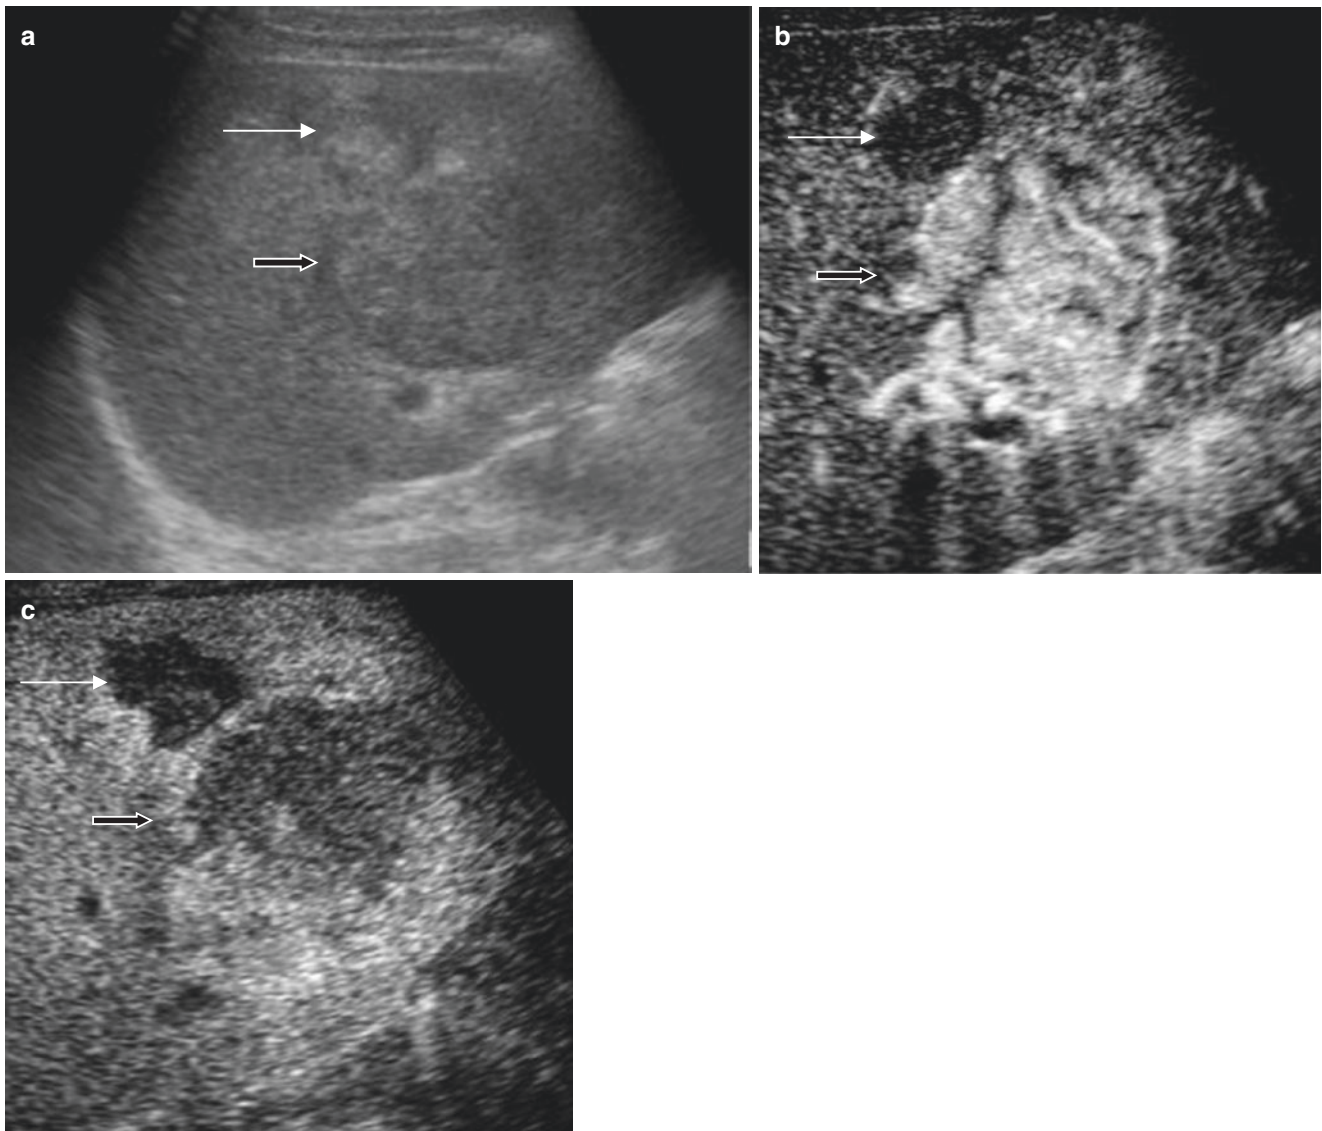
Ultrasonographic findings with or without contrast medium in hepatocellular carcinoma. The isoechoic space-occupying lesion (SOL) (short arrow) with halo and a high-echoic SOL (long arrow) are mosaic in echo pattern (a). US image with contrast medium shows high
